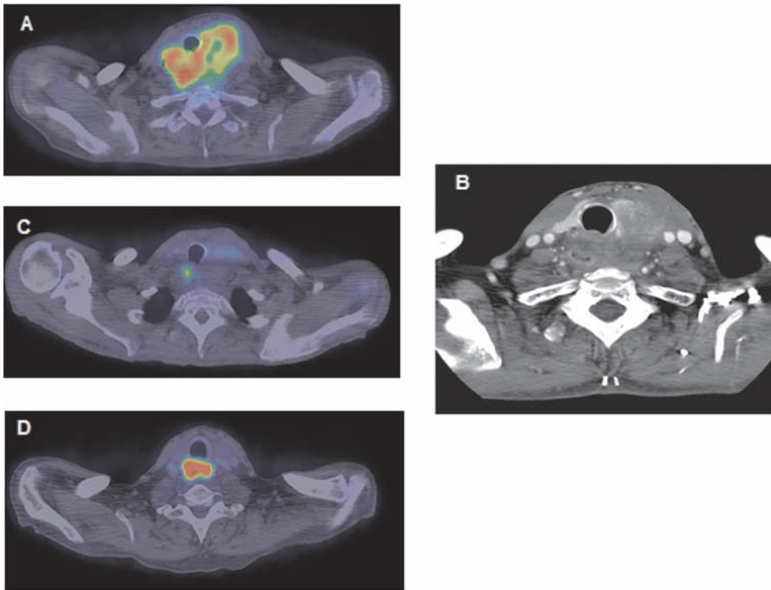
(A) Initial staging positron emission tomography (PET)/ computed tomography (CT) in patient number 7 (transaxial fused PET/CT images). (B) Contrast enhanced diagnostic CT 10 weeks after completed chemoradiation shows a large residual mass left thyroid lobe with encasement of esophagus and displacement of trachea. (C) The residual mass is negative on PET/CT except for postirradiation inflammatory uptake in esophagus. (D) Recurrent disease with intense FDG uptake 30 months later.
